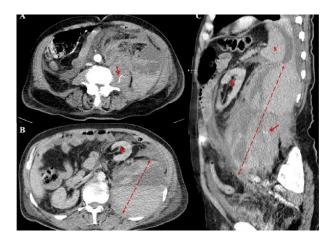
The contrast-enhanced computed tomography scan of the abdomen revealing a large retroperitoneal haematoma involving the left psoas muscle pushing the left colon and the left kidney forward and medially (A-C) with signs of contrast extravasation (arrows, A and C) S, spleen; K, kidney.
